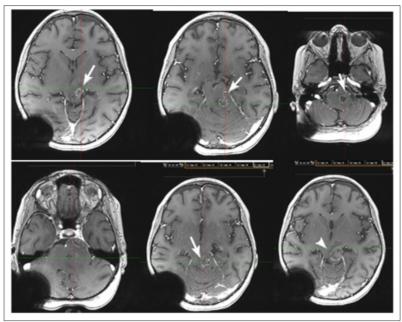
MRI image of the tumor necrosis 2 months after combined with Temodal radiotherapy, followed by 2 separate courses Temadal / white arrows show necrosis.
